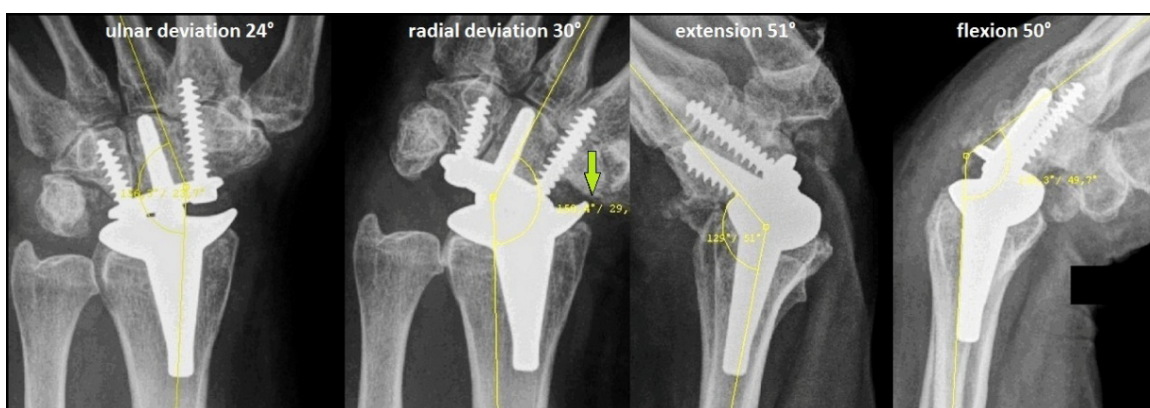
PA and lateral radiographs with terminal ranges of motion at the 2-year follow-up showing unchanged correct positioning of TWA without implant loosening or subsidence, and an excellent functional outcome without impingement at terminal range of radial deviation with 30° between the radial TWA component and the trapez bone after complete excision of the entire scaphoid bone (arrow), also noted that there is a sufficient bony support of the carpal plate size S at the capitae bone.
